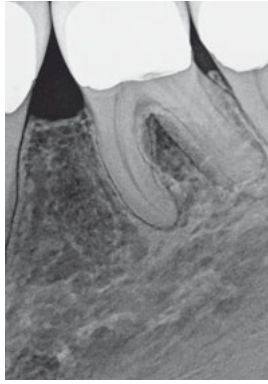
Radiograph of a mandibular molar with radix entomoralis. The dimension of the complexity of the root canal system is indicated by the postoperative eccentric radiograph in Fig 9.
